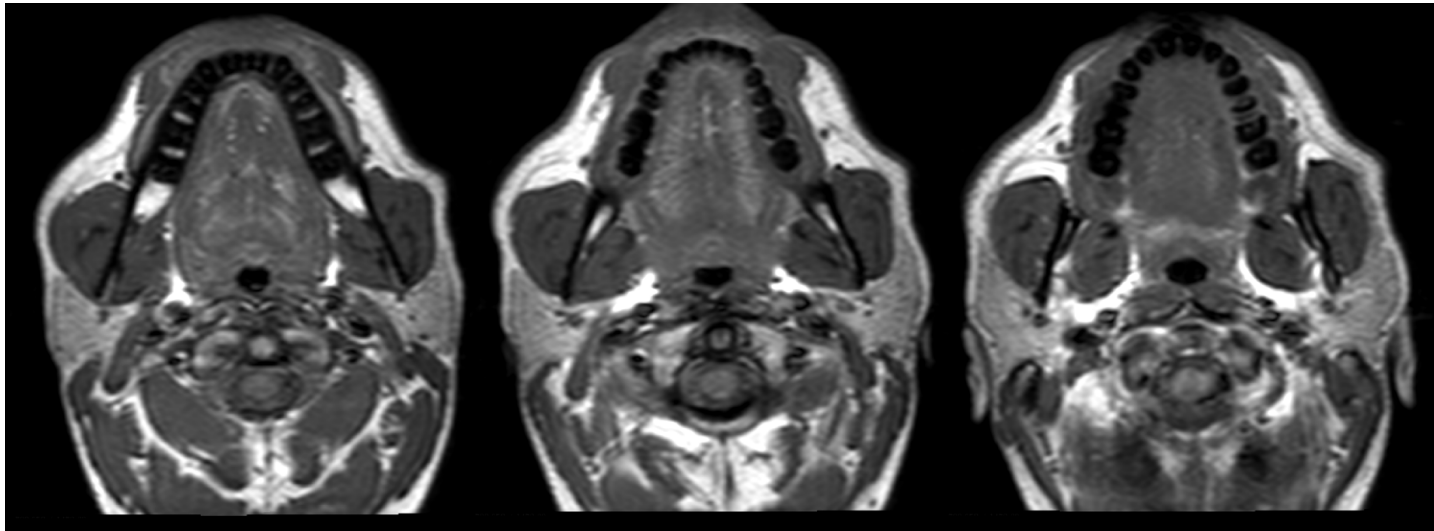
Example anatomical (T_1 -weighted, with $T_E = 16\text{ms}$ and $T_R = 619\text{ms}$) MR axial images in the vicinity of the ear canal. Tissue differentiation can generally improve upon the equivalent CT scan by adjusting the contrast sensitivity (cf. fig. 3.1). No contrast enhancement agents were administered.
